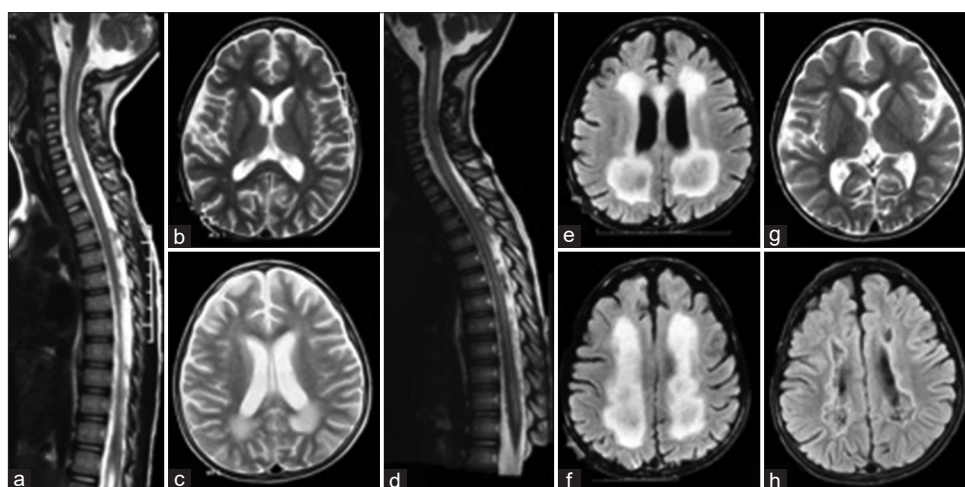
Sagittal T2 image (a) shows longitudinally extensive abnormal hyperintensity extending from pons to thoracic level of spinal cord. The brain parenchyma is unremarkable in axial T2 sections (b). Imaging on day 30 shows longitudinally T2 hyperintense signal involving the entire spinal cord (d) and large symmetrical bilateral white matter hyperintensity predominantly in the periventricular and centrum semi-ovale region with subcortical sparing on axial T2 (c) and FLAIR images (e, f). Follow-up axial T2 (g) and FLAIR (h) images at 2 years show near complete resolution of periventricular white matter changes with residual microcystic areas of rarefaction in the centrum semi-ovale
